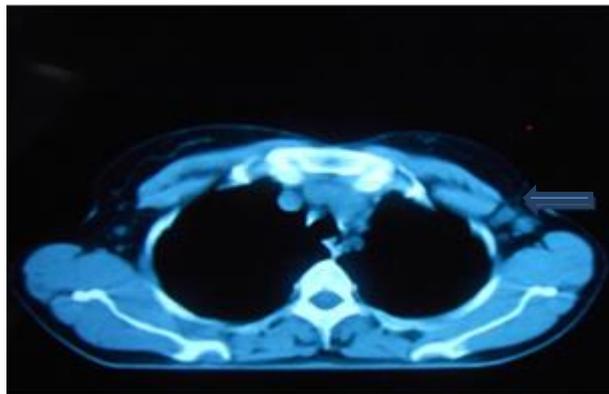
CT scan thorax showing multiple lymphnodes
